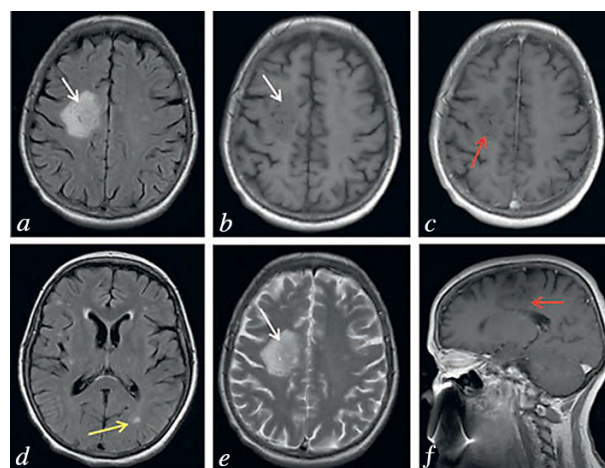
MRI brain scan with contrast November 24, 2015, T2 FLAIR (a, d), T2 (e), and T1 (b) modes, axial projection, and T1 mode after administration of contrast medium, axial (c) and sagittal (f) projections. The white matter of the frontal lobe of the right hemisphere of the brain contains a round zone with smooth, clear edges and heterogeneous structure – alternating annular zones reminiscent of annual growth rings in tree trunks (white arrows). Administration of contrast medium was not followed by pathological accumulation of medium (red arrows). In addition, the white matter of both hemispheres of the brain contains numerous plaques whose origin needs to be differentiated between vascular and demyelinating processes (yellow arrows). Comparison of MRI brain scans demonstrated improvement, with decreases in the size of the “annular” plaque in the right hemisphere of the brain and the absence of pathological accumulation of contrast medium.
